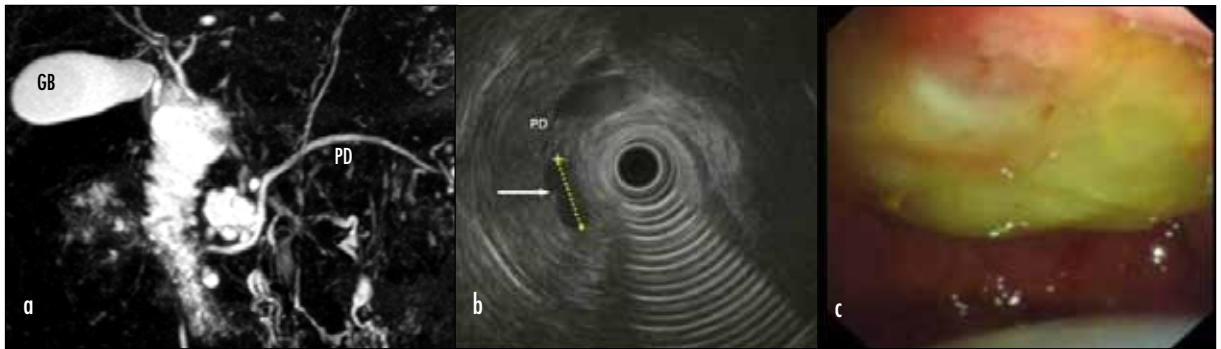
Intraductal papillary mucinous neoplasm. Incidental finding of a pancreatic cyst on computed tomography performed for investigation of small bowel obstruction. a. Coronal magnetic resonance imaging maximum intensity projection image demonstrated a multiloculated cystic structure (arrow) within the uncinate process of the pancreas which appeared to communicate with the main pancreatic duct (PD). b. Radial endoscopic ultrasound demonstrated a cystic structure (arrow) within the uncinate. c. The endoscopic view demonstrated a gaping papilla extruding mucin. GB = gallbladder.
